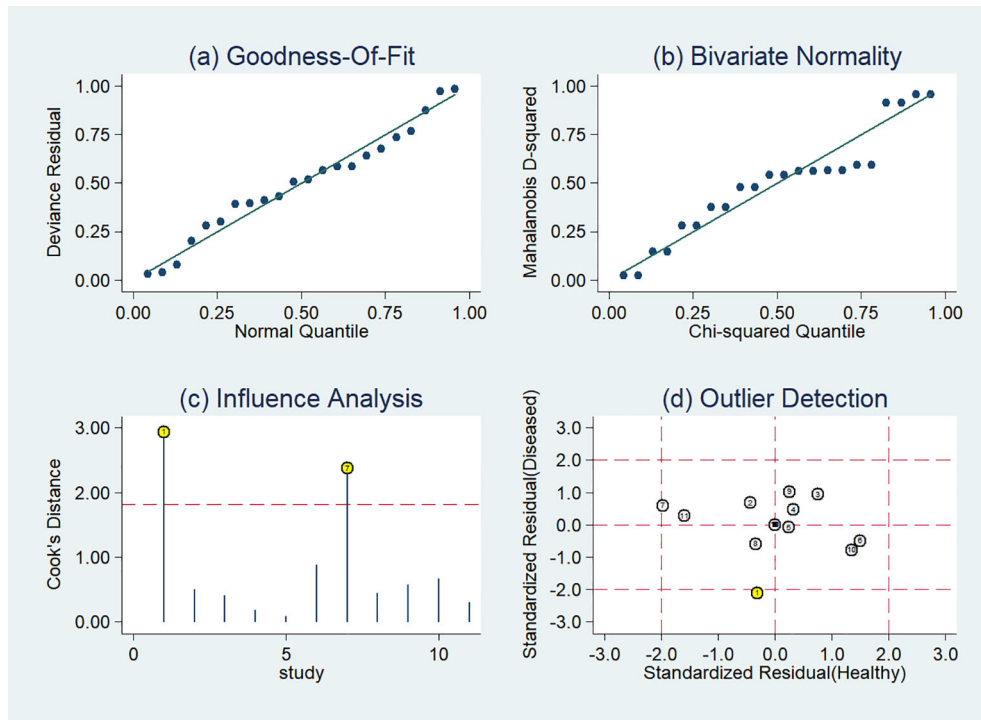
Sensitivity analysis of the included studies developing radiomics models in distinguishing between lung adenocarcinoma and lung squamous cell carcinoma utilizing CT images: (A) goodness of fit, (B) bivariate normality, (C) influence analysis, (D) outlier detection.
